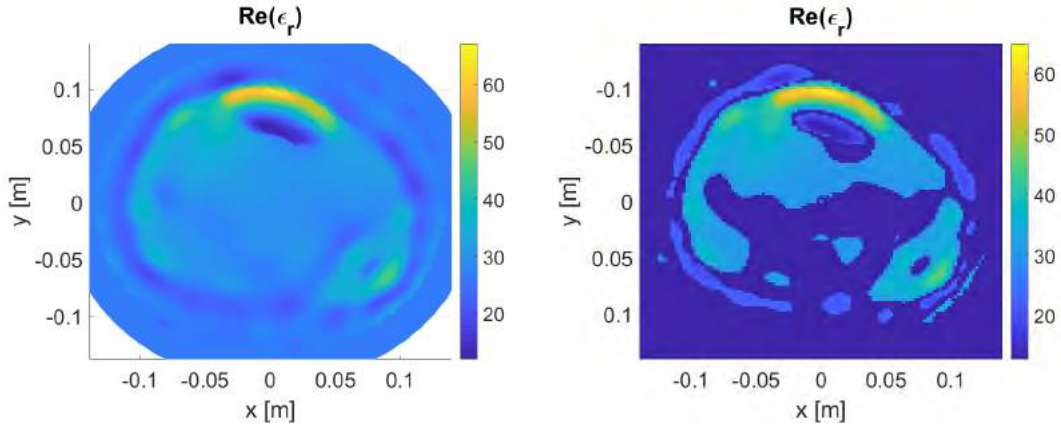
3 shows the extraction process for the three MRI models within the real and imaginary part using the Glycerin/Water solution. In addition, Figures 5.4 and 5.5 show the extraction process for the three MRI models using the ultrasound gel real and imaginary parts. The figures on the left column are the reconstructions, while the figures on the right are after conversion to a square grid and matching medium removal.
